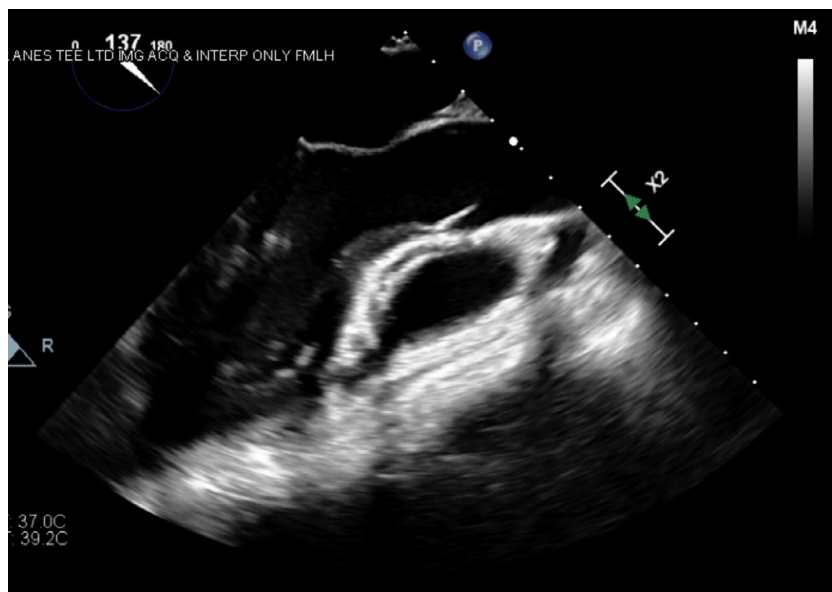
Midesophageal aortic valve long axis transesophageal echocardiography view during systole.
